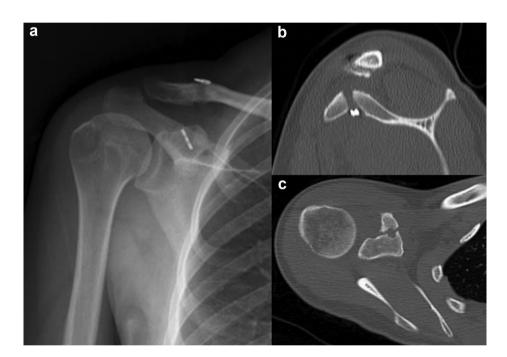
Anteroposterior X-ray (a) and CT (sagittal [b], axial [c]) views of the patient who had coracoid fracture at the postoperative third week. CT, computed tomography.
